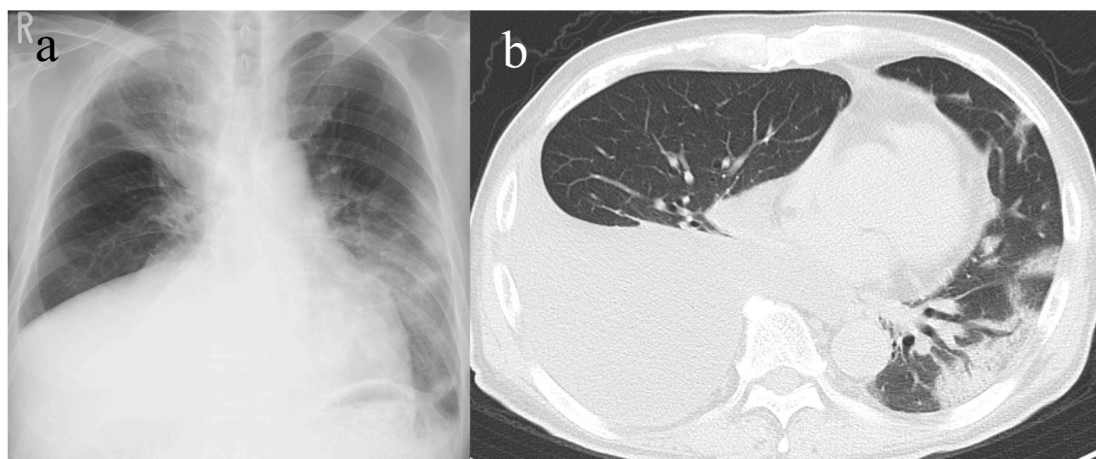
Chest imaging on admission. a: Chest radiography. b: computed tomography.
